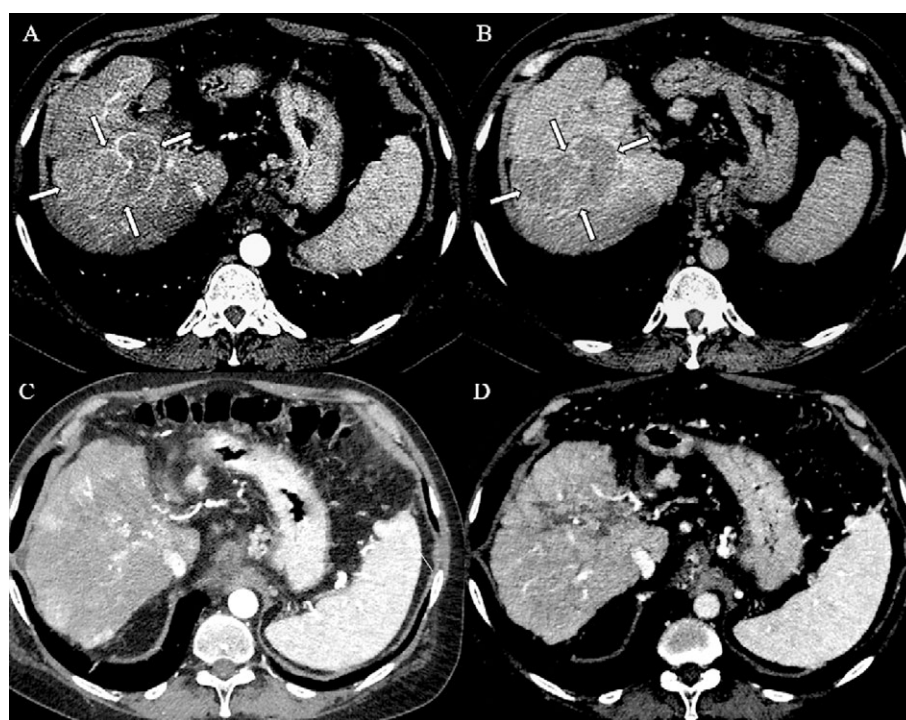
A, B) Computed tomography images: nodule in the liver segments V-VIII, with a maximum diameter of 8 cm, with hypervascularization in the arterial phase (A) and wash out of contrast media in the venous phase (B), compatible with the accepted imaging diagnosis of hepatocellular carcinoma. C, D) Computed tomography images of the same patient, performed after Sorafenib administration: the images in the same planes as in panels A and B, demonstrate the absence of liver lesions both in the arterial (C) and in the venous phases (D).
